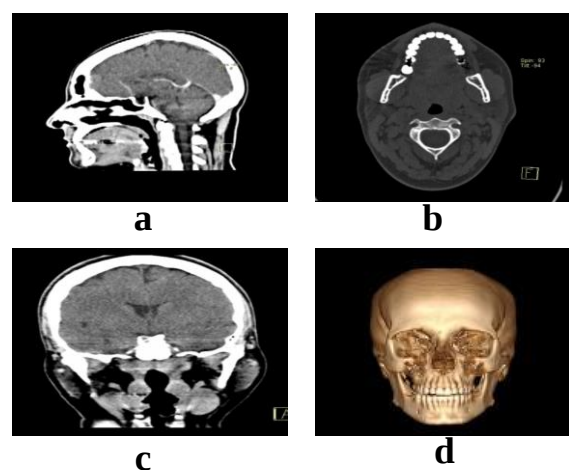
Different views of CT scan (a), coronal view; (b), axial view. (c), sagittal view; (d), 3D rendered CMF model.
